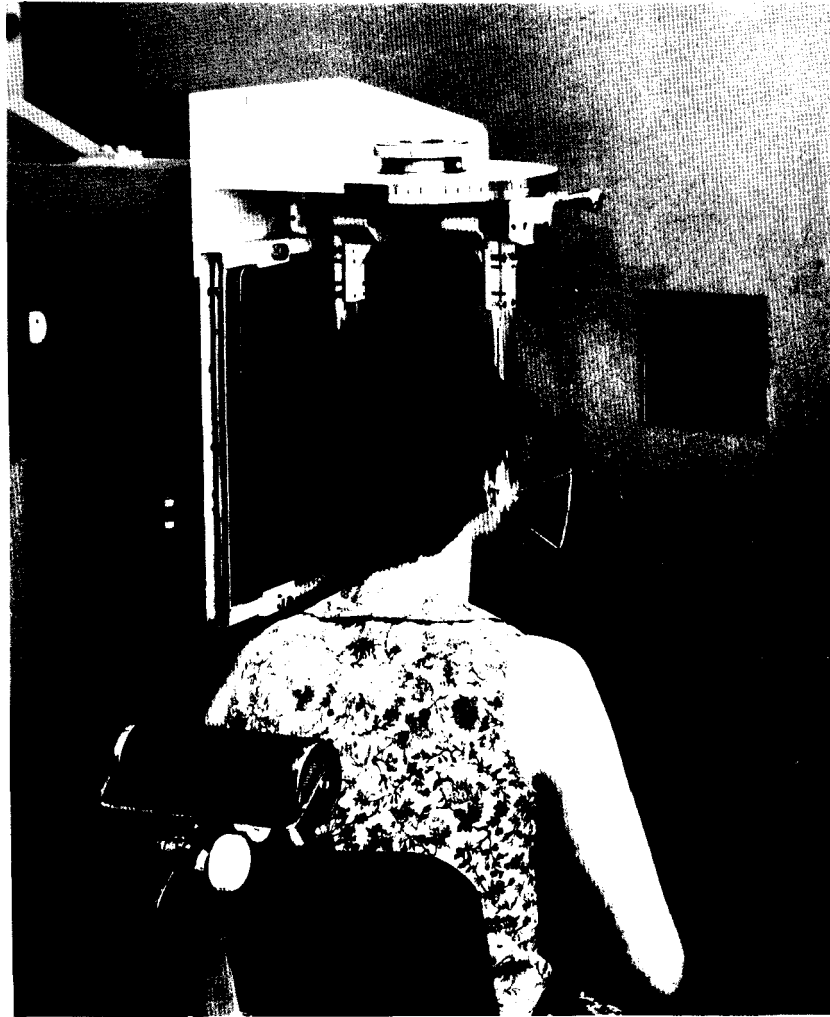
An Adams' Cephalostat. The ear posts are adjustable to position the subject's head at a constant midline distance from the cassette holding the x-ray film, and so assure a constant enlargement for all subjects. The x-ray source is positioned at right angles to the cassette at a distance of 165 cms.
